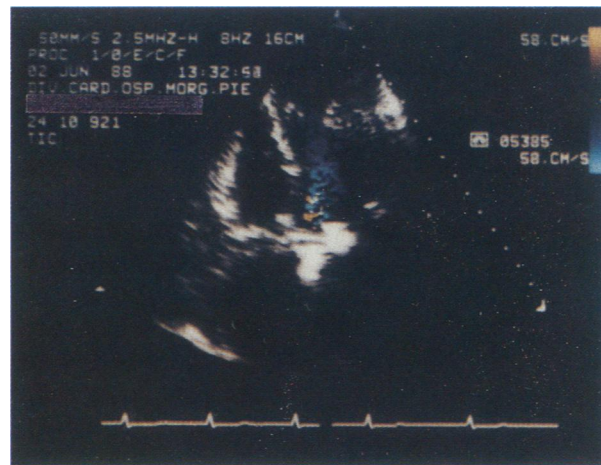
Color-flow Doppler image of a 27-mm Medtronic-Hall monoleaflet valve shows regurgitant jet across the valve in the apical 5-chamber view. Despite this evidence, no negative hemodynamic consequences were found.
